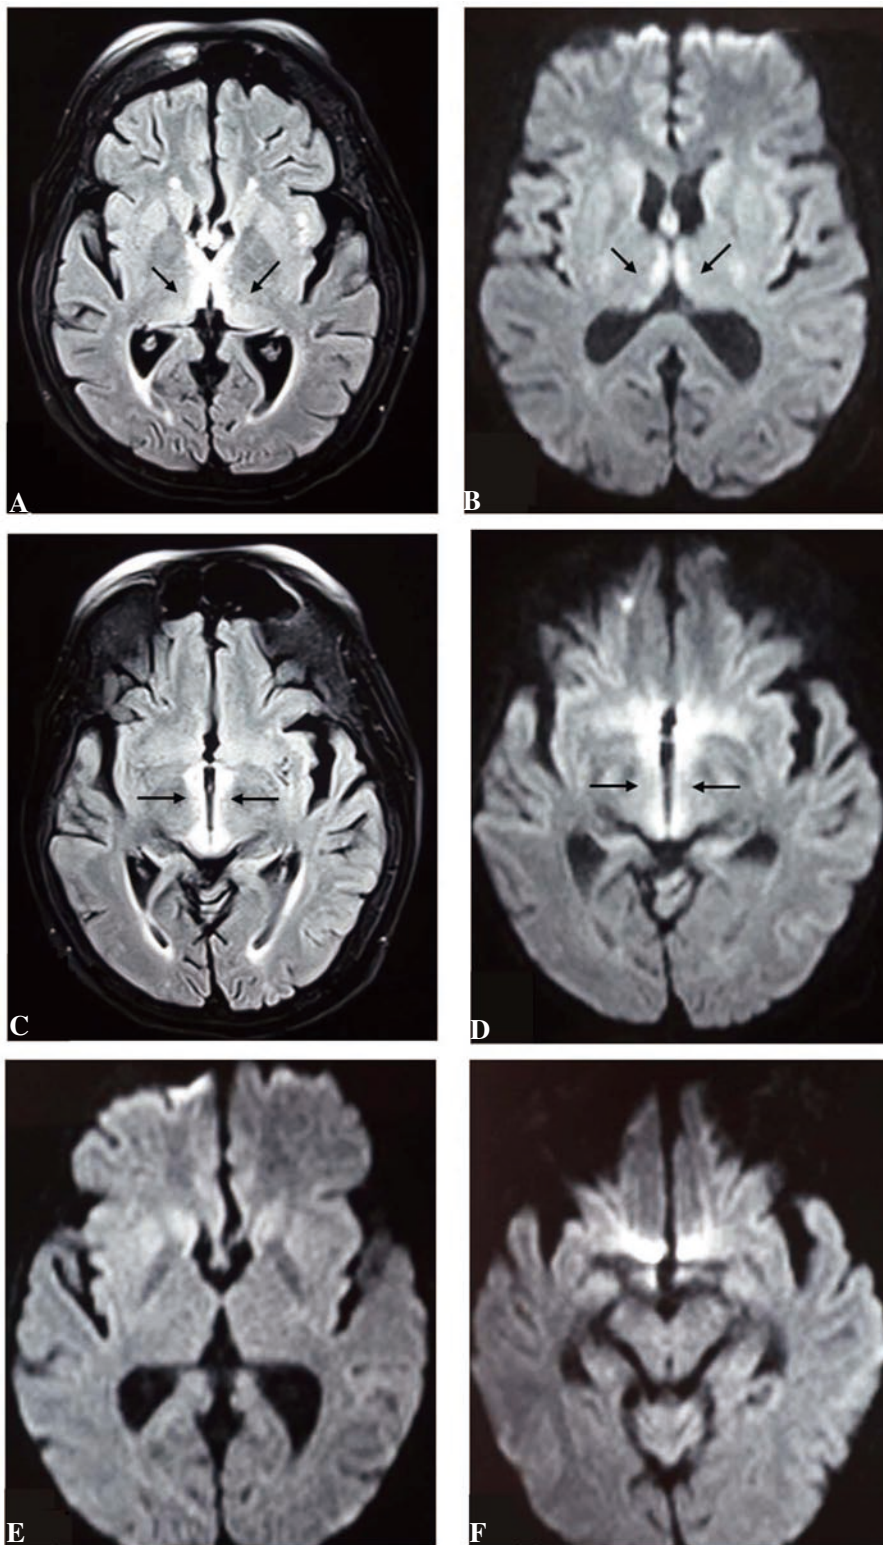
Pre-treatment axial MRI (FLAIR and DWI) of the brain. A and B: bilateral symmetrical hyperintensities and diffusion restriction in the medial thalami (arrows); C and D: periaqueductal grey matter (arrows); E and F: post-treatment axial DWI of the brain shows resolution of signal changes previously seen.
